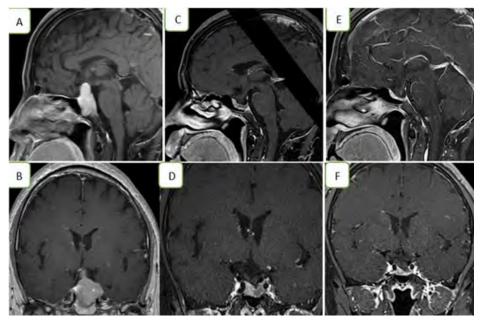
MRI: Before and after treatment with bromocriptine.
